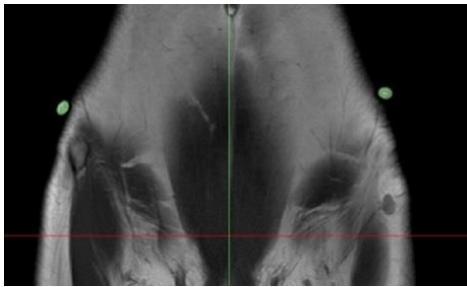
ASIS (a) and Sacrum (b) markers are applied for defining pelvis coordinate system and are visible in MRI data (data belongs to subject AB).
